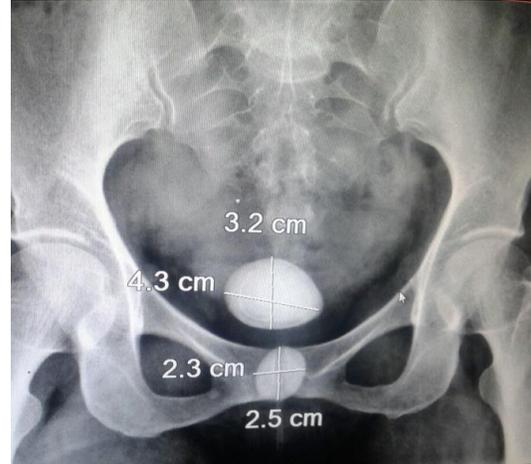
Plain X-ray pelvis showed vesical and urethral calculi.
